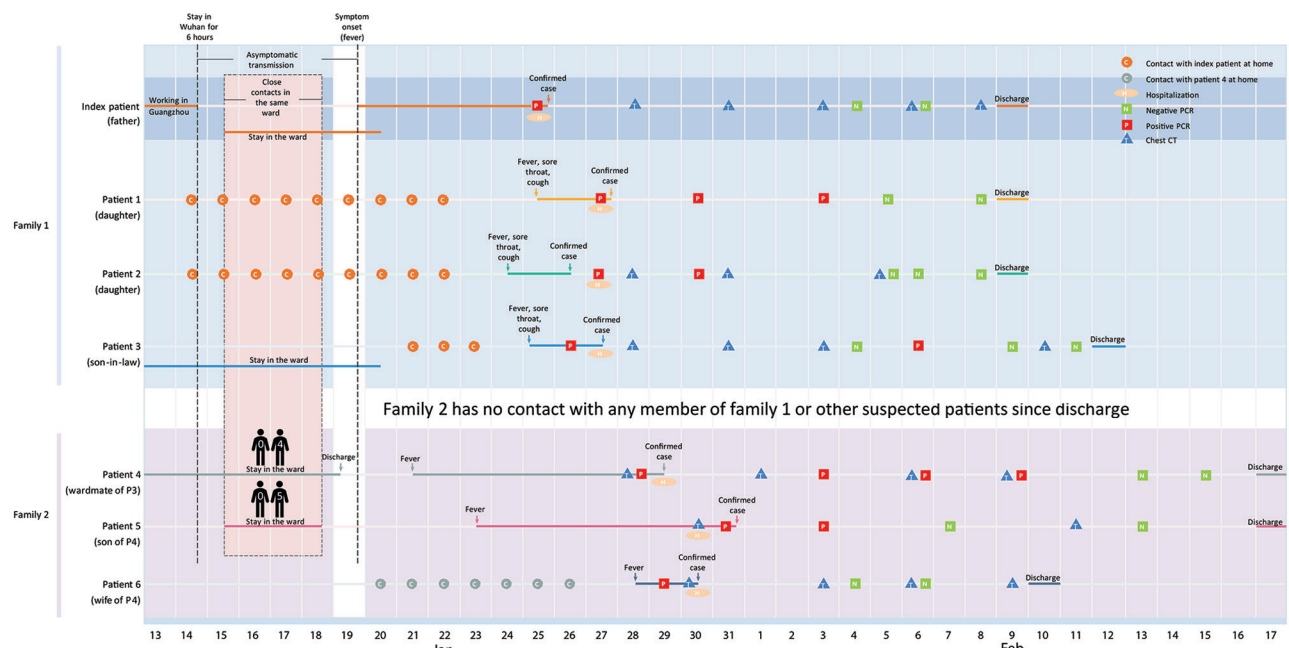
Chronology of a 2-family cluster of severe acute respiratory syndrome coronavirus 2 infection, including travel and contact history, in familial and hospital settings, Xuzhou, China, January 13–February 17, 2020. Dates of case confirmation, hospitalization, and discharge are labeled. Real-time fluorescent reverse transcription PCR for severe acute respiratory syndrome coronavirus 2 infection and corresponding results are indicated, together with the dates of chest CT. CT, computed tomography.
